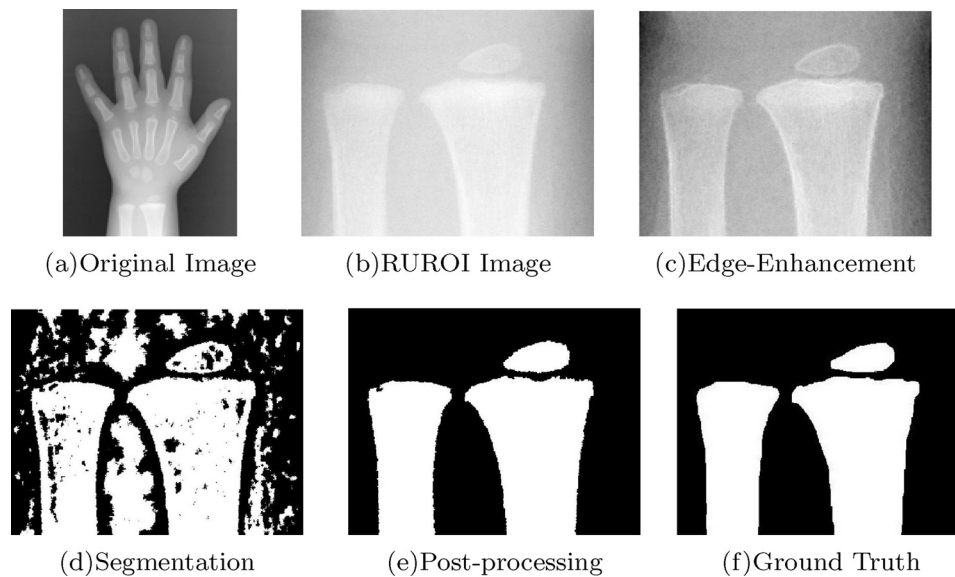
Output images from each stage of the proposed technique on hand radiograph of 1 year old [5173.jpg].
